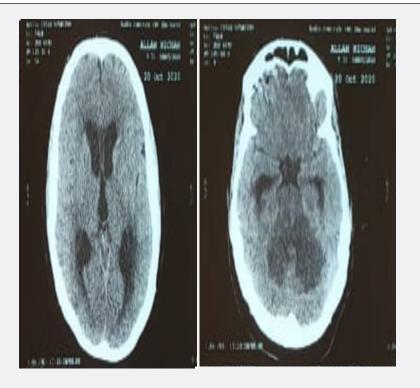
A brain CT scan showing bilateral cerebellar hypodensity with a mass effect, on the brainstem, and a triventricular hydrocephaly.
